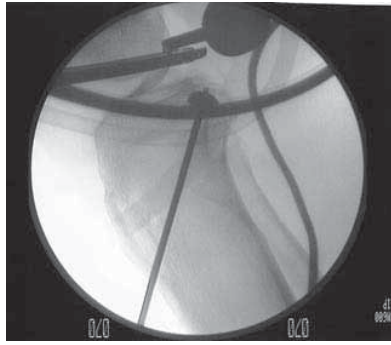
Radiographic lateral view of the 8- to 10-mm posterior tibial inlay socket.
